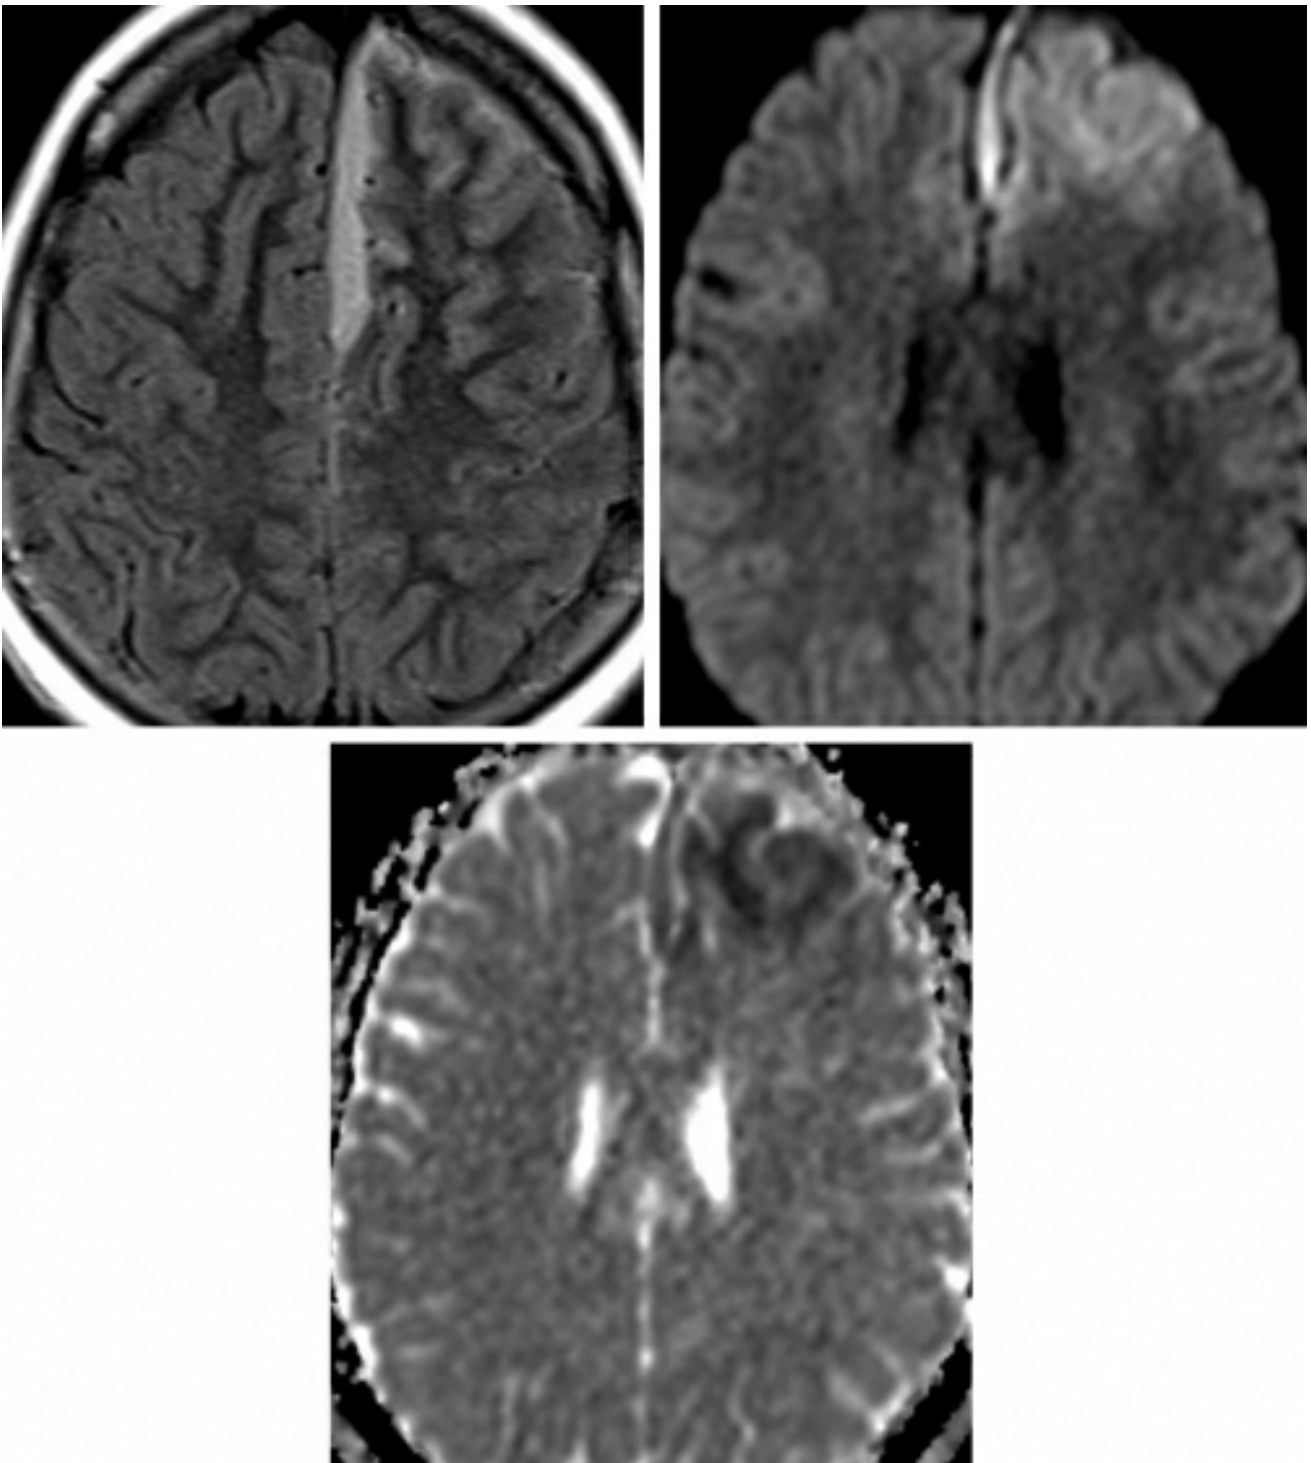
10 year-old male with meningitis and subdural empyema. A subdural empyema in the left parafalcine subdural space is intermediate in signal intensity on FLAIR image (top row left) reflecting incomplete suppression of this fluid compared to CSF because of the cellular debris within the infected fluid. Also notice the subtly increased signal in the left frontal lobe cortex and leptomeninges likely representing a combination of cerebritis and early changes of ischemia and meningitis, respectively. The parafalcine collection also
